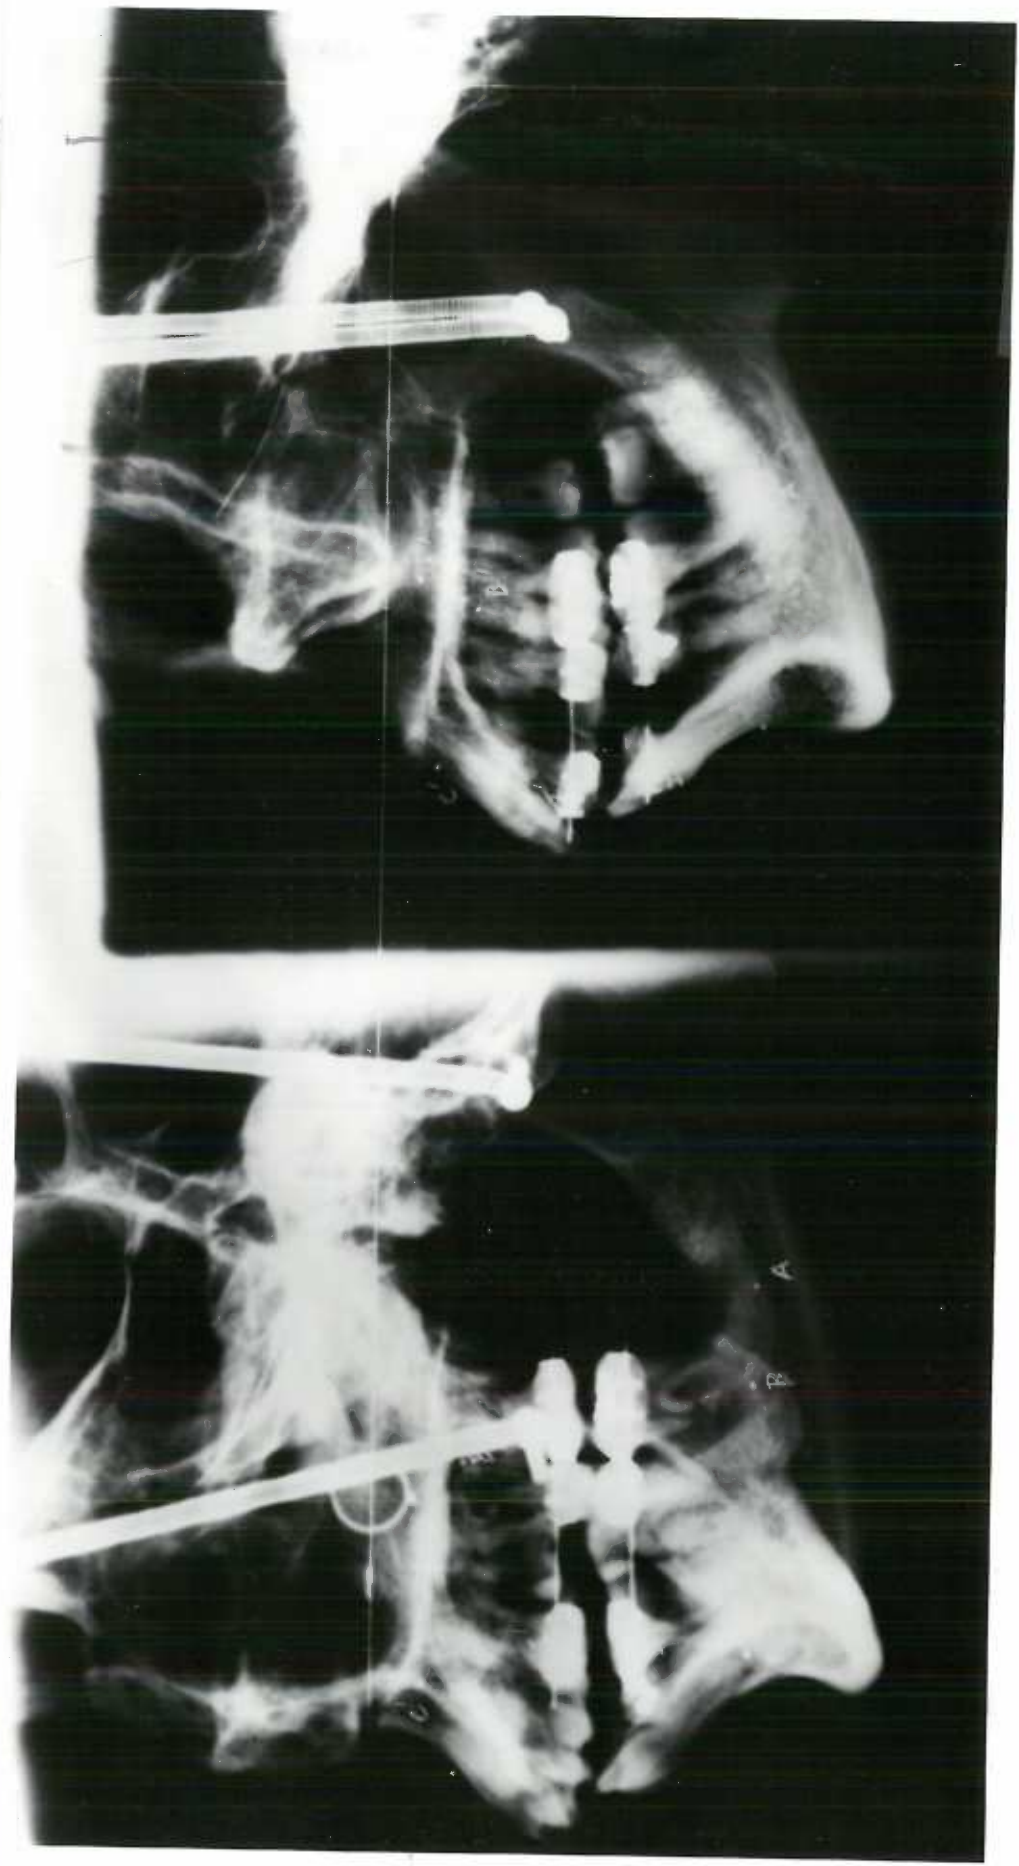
Radiograph taken by the three dimensional cephalometric technic
